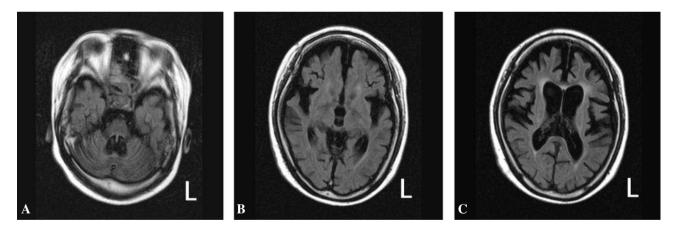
A, B, C. MRI with axial sequences at age 21 showing diffuse brain atrophy including the cerebrum, brainstem, and cerebellum.
